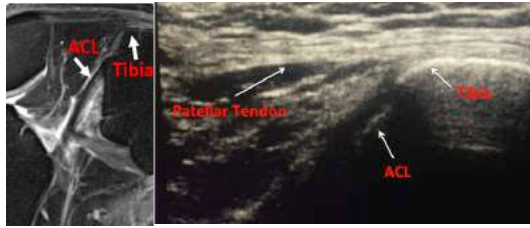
MRI image of the ACL (left), Ultrasound image of the ACL (right)
